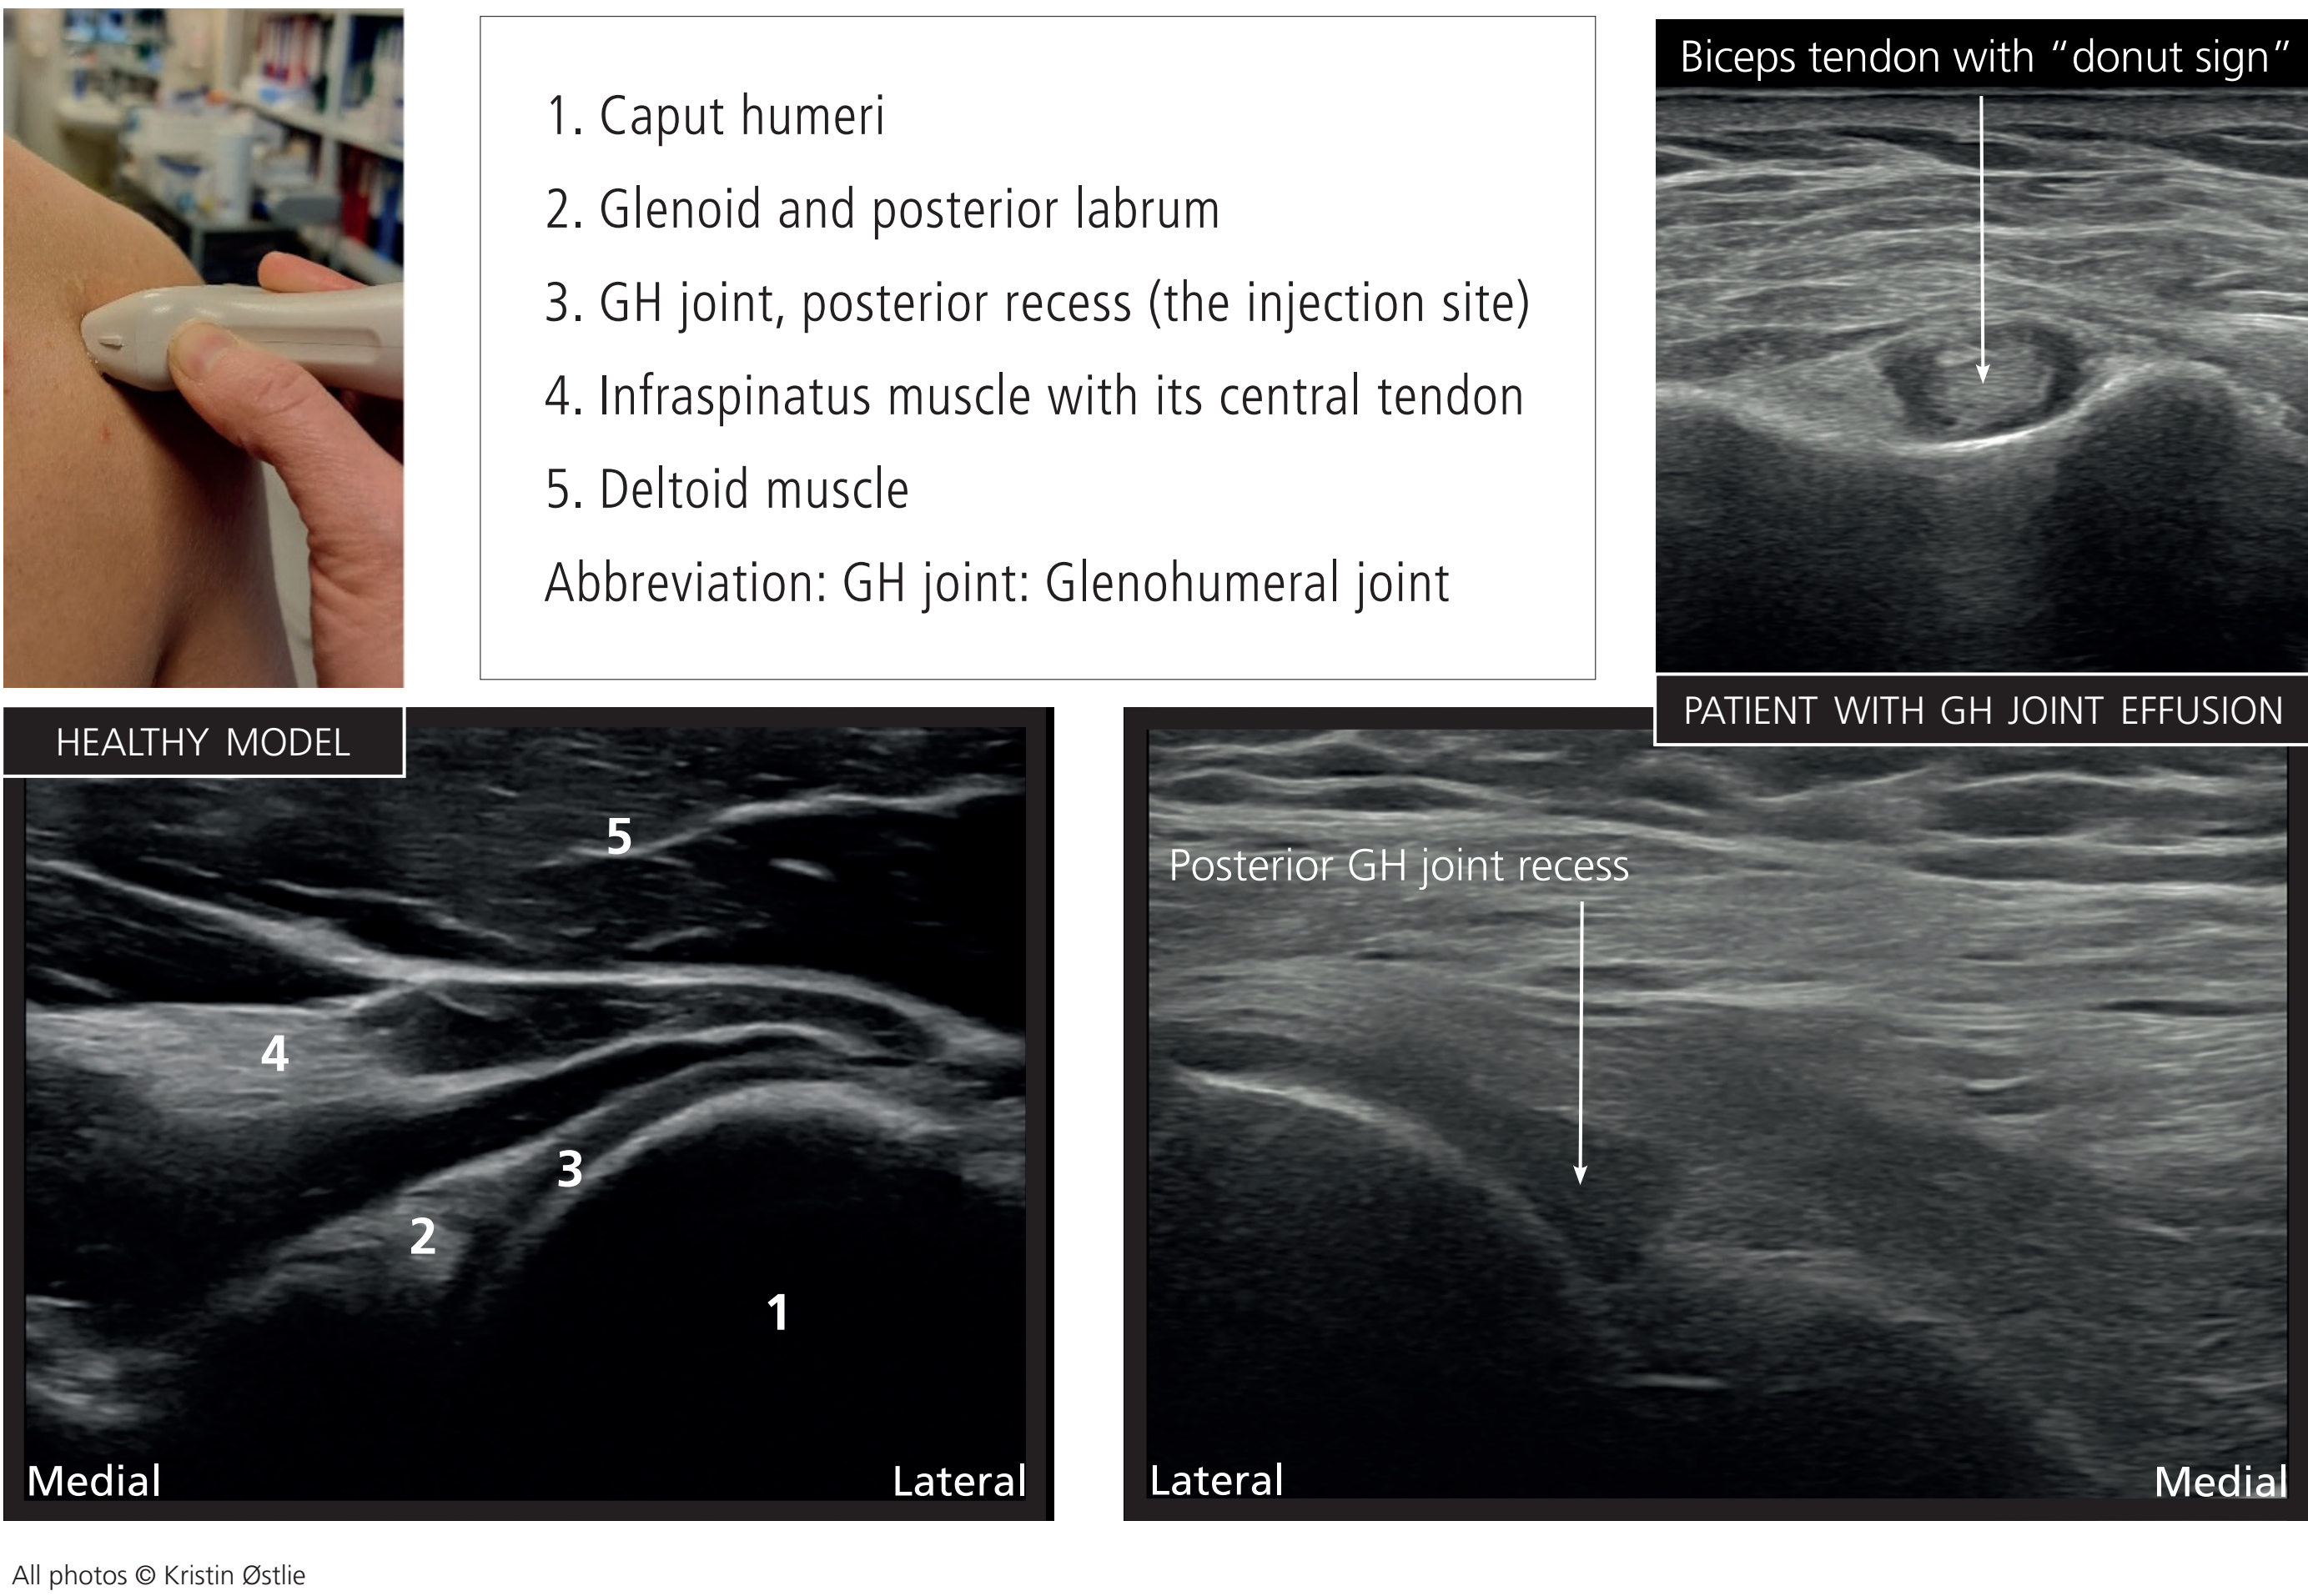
Ultrasound-guided GH joint injection
